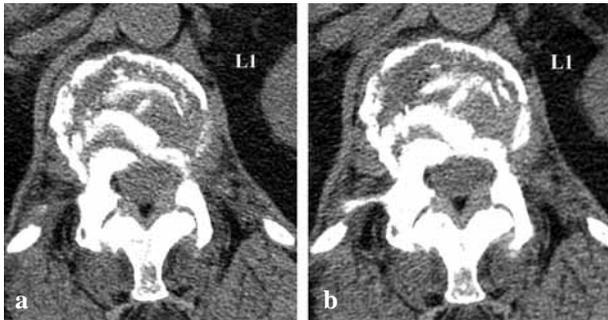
Preoperative CT at the level of L1 of the same patient : Traumatic incomplete superior burst fracture of L1, the endplate of the vertebra is totally destroyed, the posterior wall is involved.
